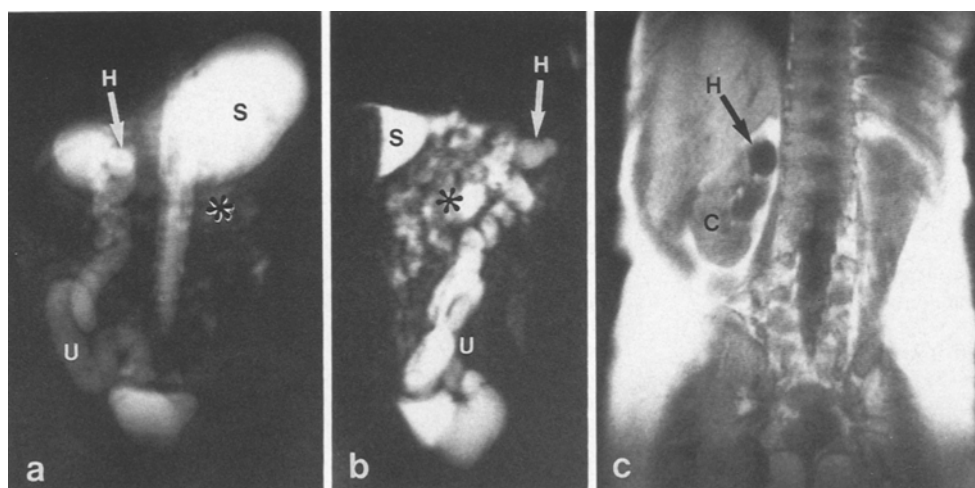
2-month-old boy with urinary tract infection. a Coronal RARE-MR-urography, b right sagittal RARE-MR-urography – corresponding to a lateral view, c coronal T1-weighted image: renal duplication on the right with hydronephrotic cranial segment (H) and draining megaureter (U), normal caudal segment (C) without dilatation of lower collecting system. Fluid in the gastrointestinal tract (S = stomach – with air-fluid level in b –, * = small bowel), which leads to superposition in (a), but can be ascribed to stomach and small bowel in (b)
